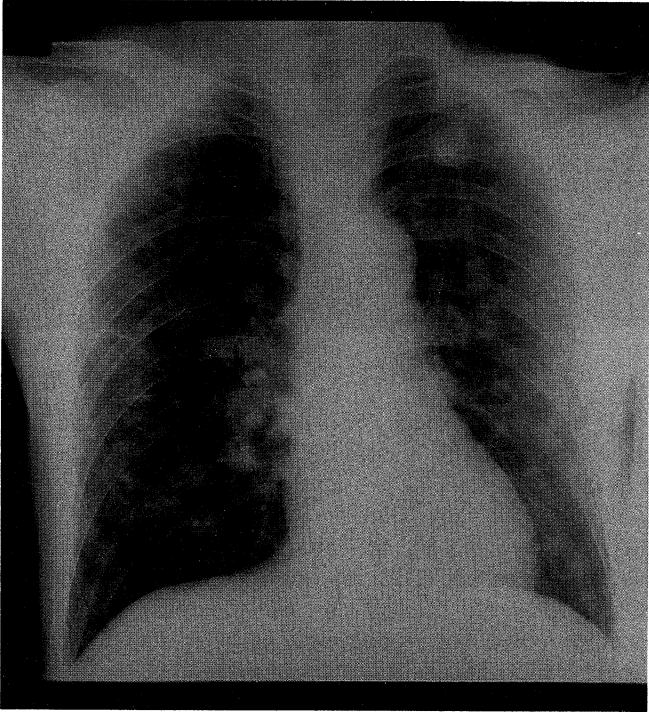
Chest X-ray Film on admission
